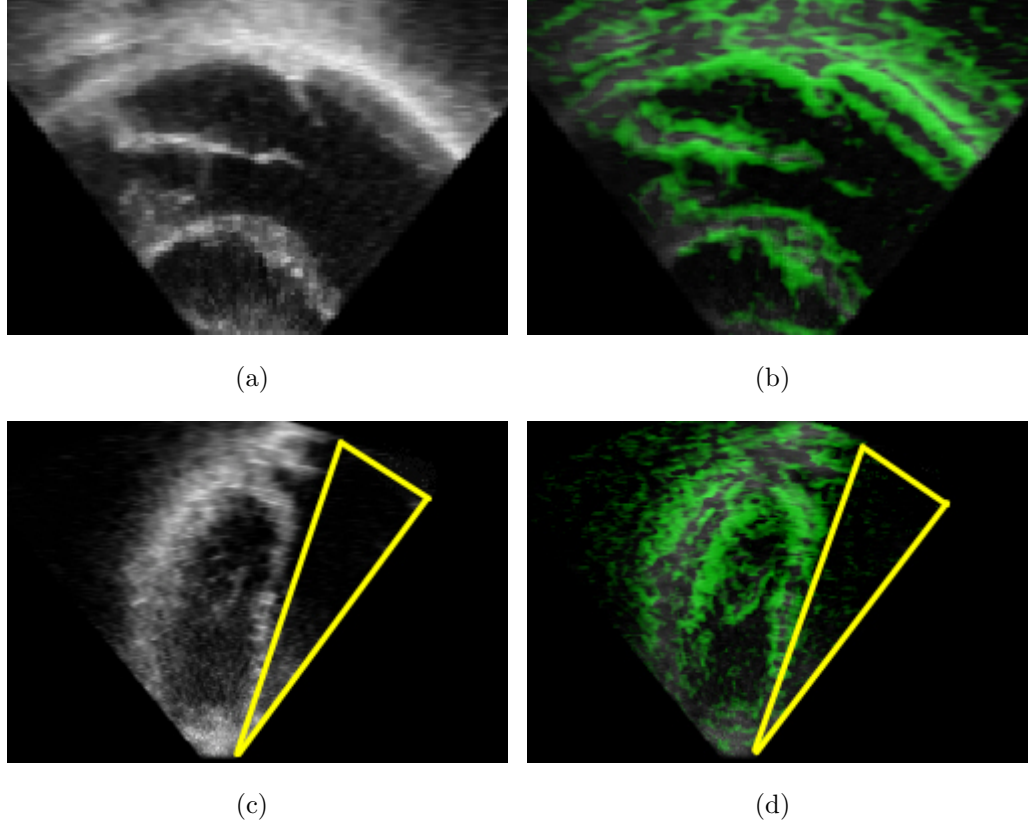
Example of regions highlighted by weight w_1 (weighting values are normalized between 0 to 1). (a) single original image slice showing the parasternal long axis view; (b) w_1 was calculated and overlayed with the original image showing boundaries (the “double edges” on the valve occurs when there are two step edges i.e. the changes of acoustic impedance happens; (c,d) are presented in the same way as (a,b), but with an artefact region (due to shadowing) labeled with triangle. As expected, w_1 shows low weighting values inside the artefact region.
